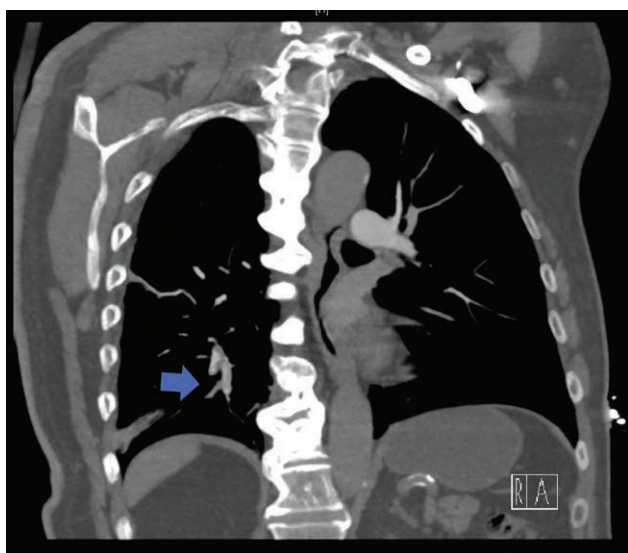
Computed tomography angiogram demonstrated filling defects within the branches of the right lower lobe pulmonary artery (arrows), consistent with acute pulmonary emboli.
